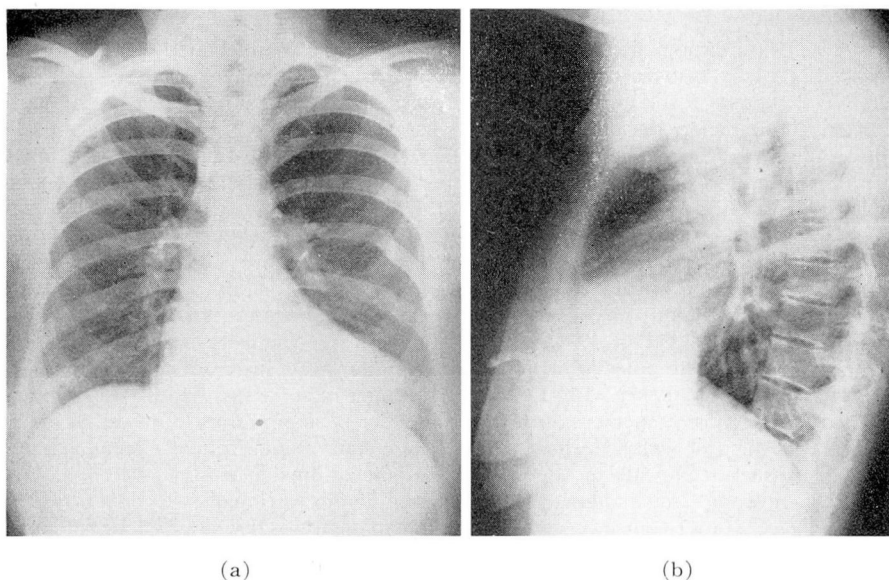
(a and b) Anteroposterior and lateral roentgenograms of chest demonstrating mediastinal lesion.
